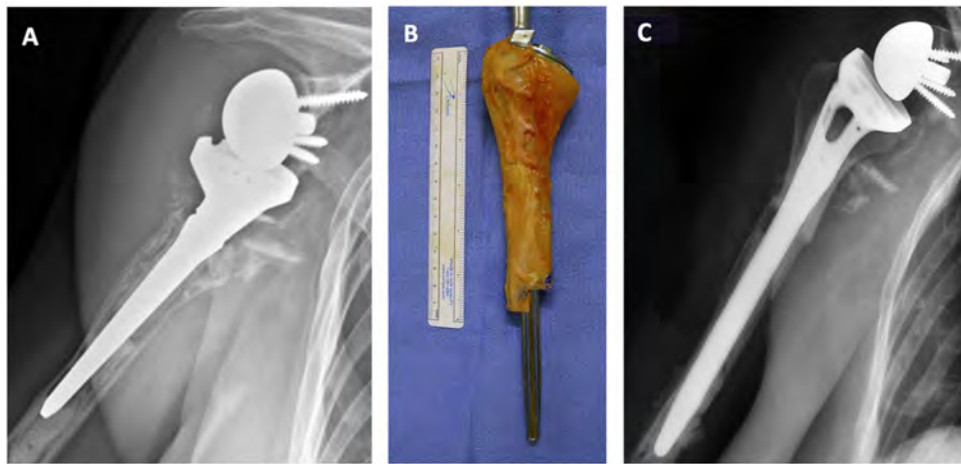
Example of humeral loosening with severe bone defect. A. Preoperative radiograph. B. Humeral allograft with “step-cut”. C. Postoperative radiograph.
